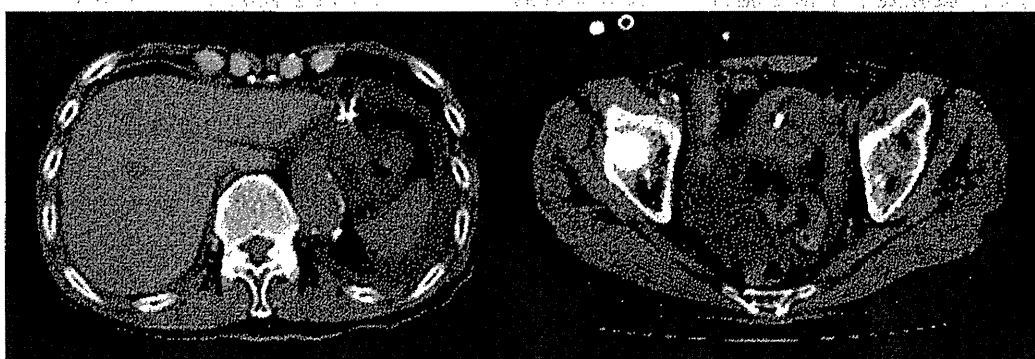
Abdominal CT demonstrated free air and fluid collection in the abdominal cavity 16 hours after ESD.
